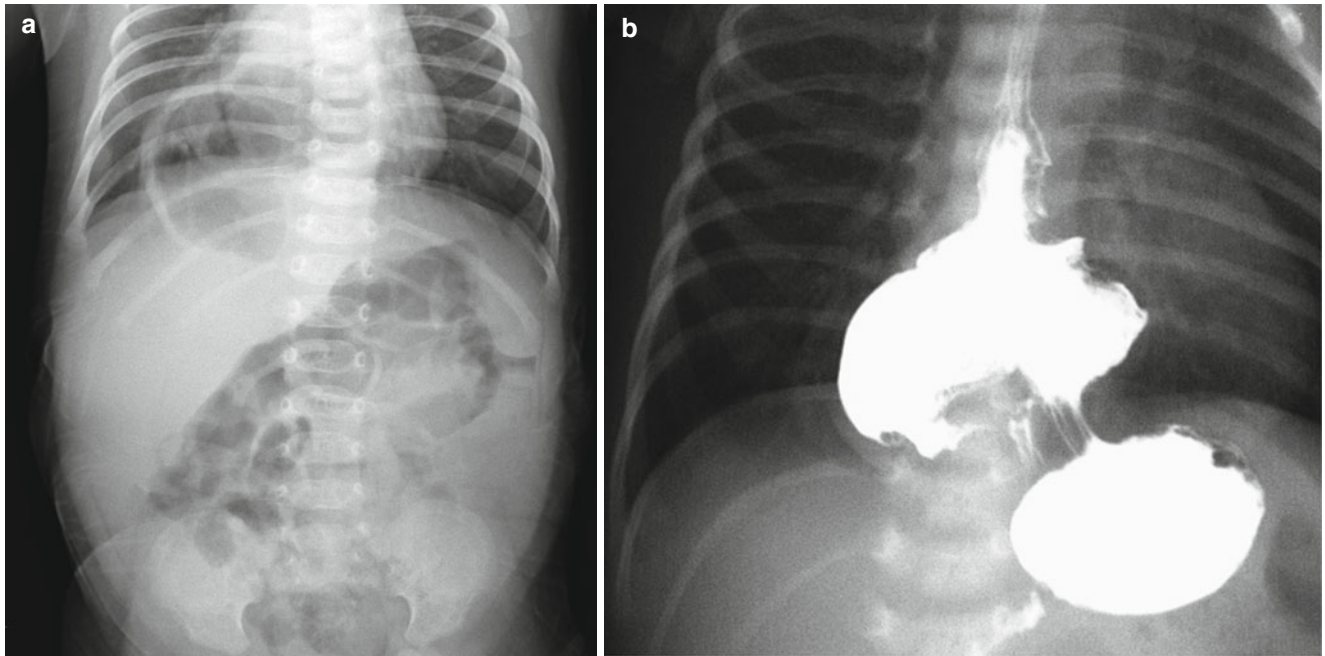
Organoaxial volvulus in a 12-day-old neonate with hiatal hernia. (a)* Plain radiograph shows air-filled structure with an unusual configuration in the retrocardiac and right paravertebral areas. (b)
